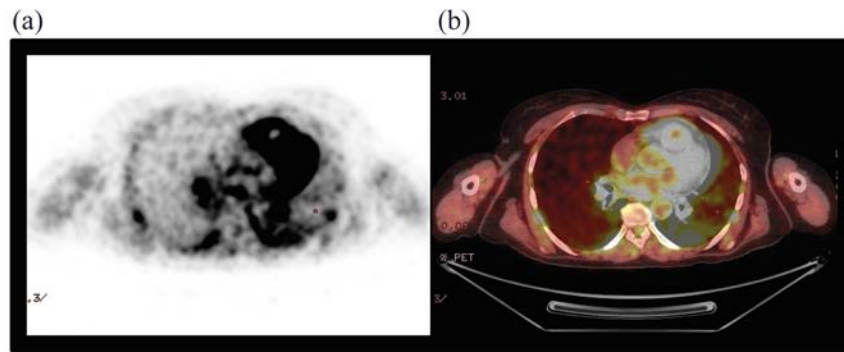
Transaxial AC-PET (a) and fused AC-PET/CT (b) images from the overlapped region marked by the arrow in Fig. 4.16. AC: attenuation corrected.
